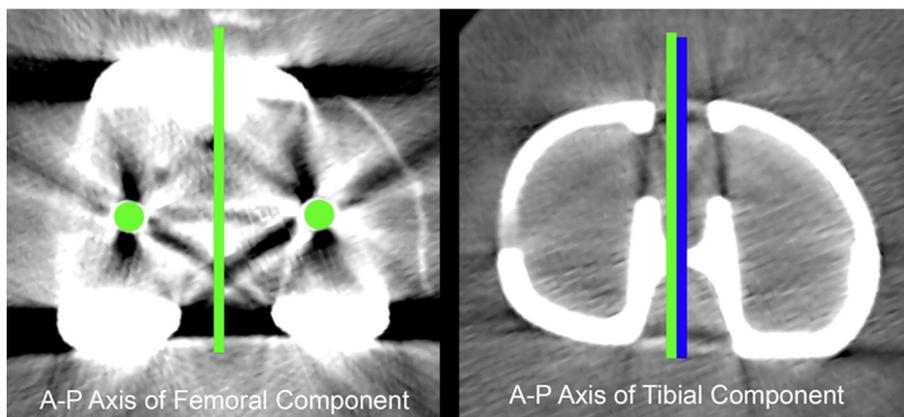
The axial CT view of the femur (left) that best shows the femoral fixation lugs (green circles) is selected. The A-P axis of the femoral component (green line) is drawn perpendicular to a line connecting the center of the lugs (not shown). The axial CT view of the tibia (right) that best shows the proximal surface of the anatomically shaped tibial baseplate is selected. The A-P axis of the tibial component is drawn bisecting the anatomically shaped tibial component (blue line). In this example the angle between the A-P axis of the femoral and tibial component is 0° .
